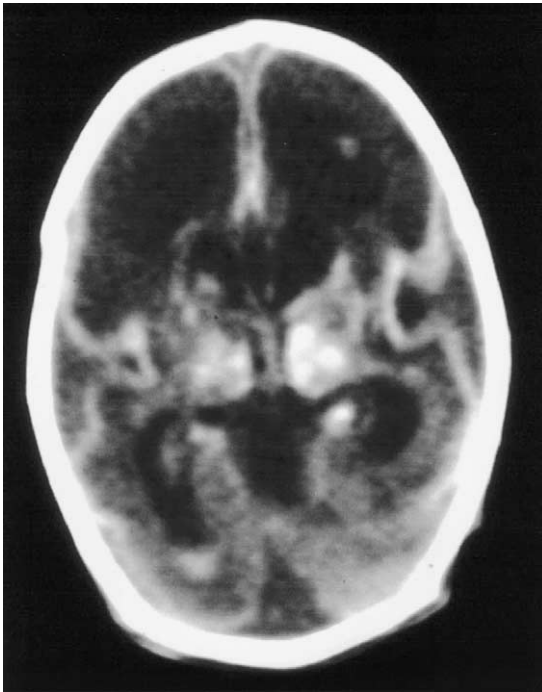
An unenhanced head CT scan of a neonate with intrauterine herpes simplex virus (HSV) infection shows dense calcifications of the deep nuclei, diffuse white matter hypodensity, and cortical dysplasia resembling lissencephaly.
